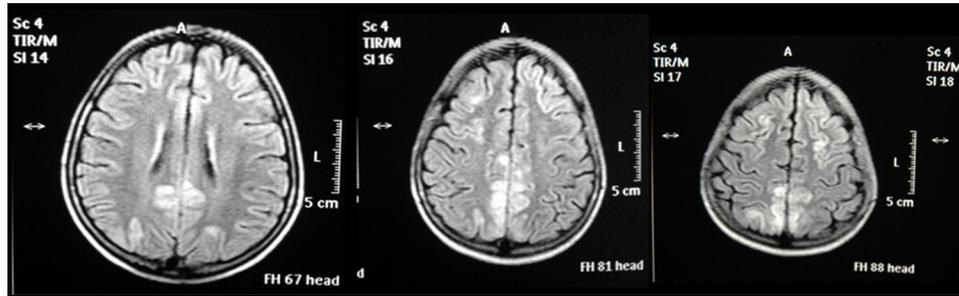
Magnetic resonance imaging showing altered signal intensity of cortex and subcortical white matter in bilateral posterior parietal, occipital region and bilateral frontal region appearing hyperintense on T2-weighted and fluid-attenuated inversion recovery images and hypointense on T1-weighted images
